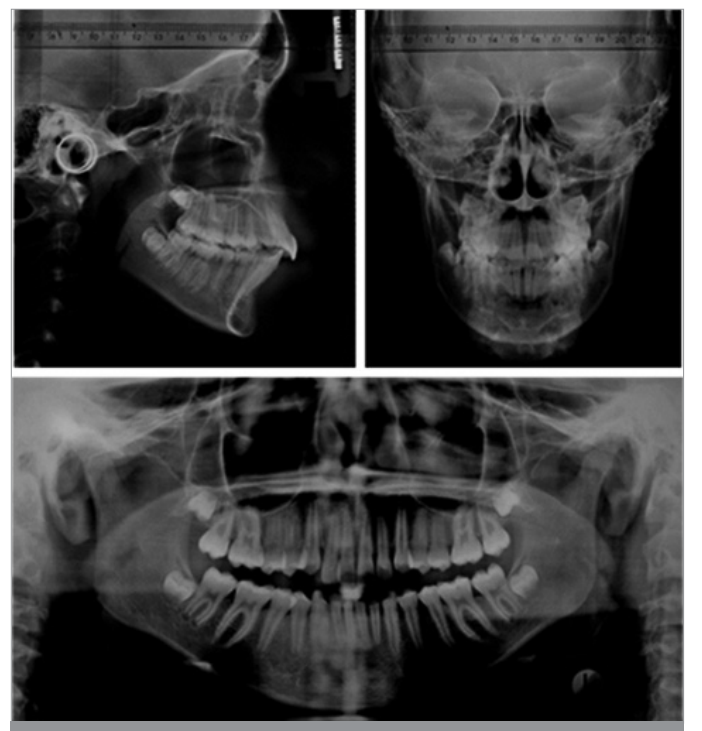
Pre-treatment lateral and posteroanterior cephalometric and panoramic radiographs
